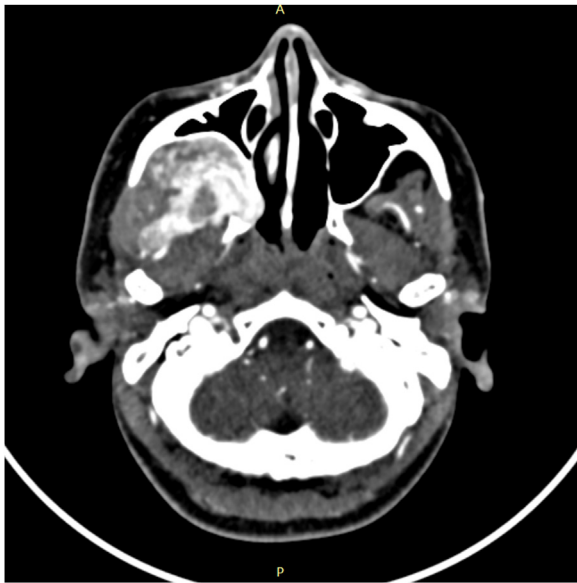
Computed tomography (CT scan) showing a tissue density voluminous and intensely enhanced mass of the right Infratemporal Fossa.
